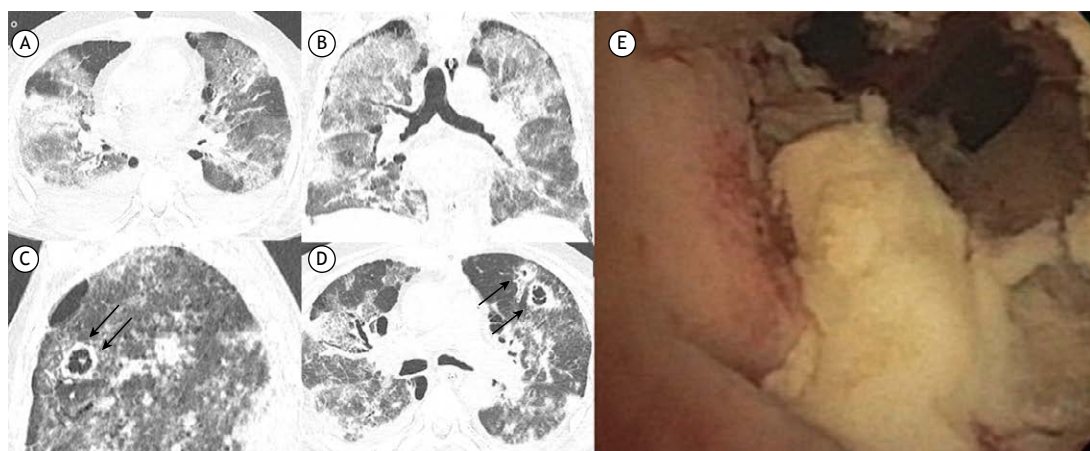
In A and B, respectively, axial and coronal CT scans of the chest showing extensive bilateral ground-glass opacities, associated with fine reticulation and small foci of consolidation, consistent with COVID-19. Note also bilateral pleural effusions. In C and D, respectively, sagittal and axial CT images of the chest showing cavitated pulmonary lesions (arrows) in the left upper lobe, superimposed on the findings of COVID-19. In E, bronchoscopic findings of grossly necrotic tissue and yellowish secretion, suggesting fungal colonization.
